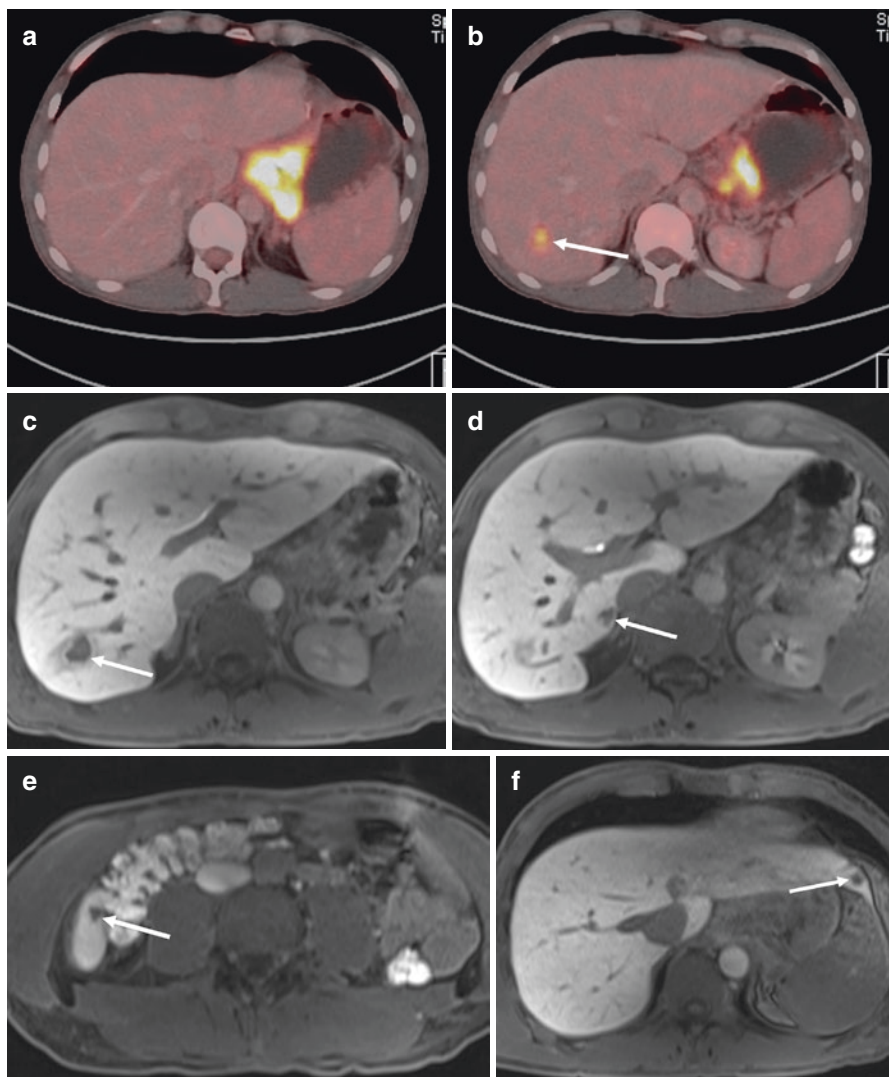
Added value of liver MRI in a young patient with a bulky Barrett carcinoma. A 35-year-old male patient with a bulky Barrett carcinoma (clinical stage T4a, node positive), underwent [18F]-FDG-PET/CT for staging. Apart from the primary tumor (a), one metastasis with pathologic FDG uptake is appreciated in Segment VII of the liver (b, arrow). In the backdrop of the patient age and the solitary metastatic site on [18F]-FDG-PET/CT, a treatment plan to resect the primary tumor with intraoperative ablation of the liver metastasis after induction therapy was created. For further workup, a liver MRI with application of a hepatocyte specific contrast agent was conducted (c–f: Gadoxetic acid—enhanced MRI, axial T1-gradient echo sequence with fat saturation in the hepatobiliary phase). In addition to the already known metastasis in Segment VII (c), three more metastases were detected in Segments V (d), VI (e) and III (f), indicated by arrows. The treatment plan was abandoned and palliative chemotherapy was initiated
